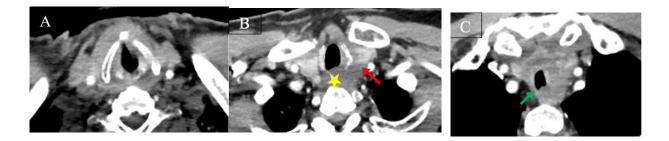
Axial CT scans centered on the cervical region with contrast-enhanced iodine injection.
